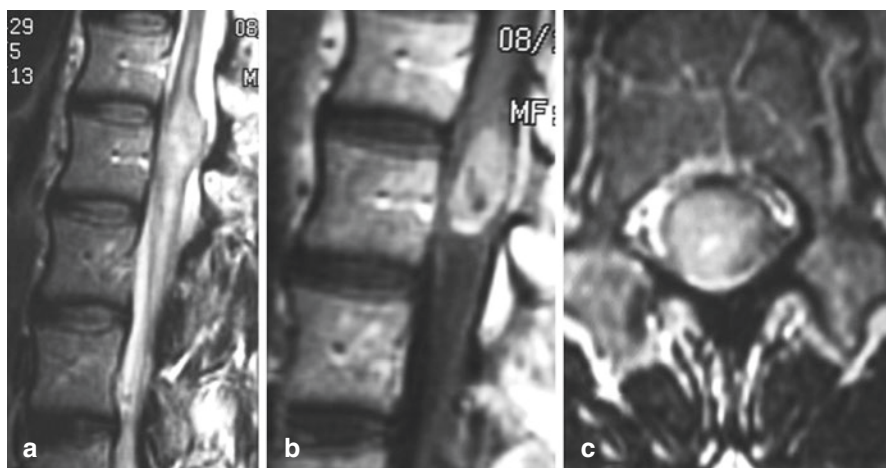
Anaplastic ependymoma. Sagittal (a, b) and axial (c) MRI of the thoracic spine showing relatively centralize lesion with strong enhancement and adjacent syrinx
